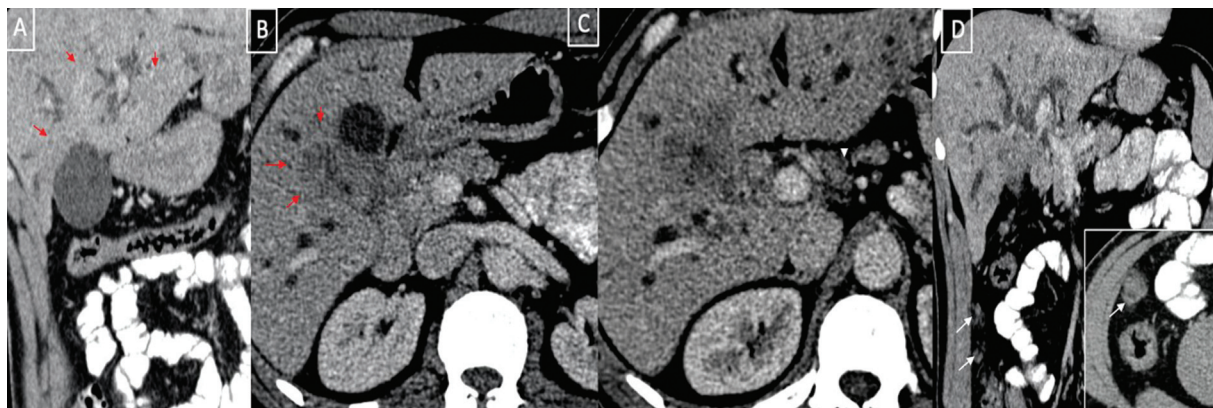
Multiplanar reformatted contrast-enhanced computed tomography image of a 56-year-old male with malignant gallbladder wall thickening. Sagittal (A) and axial (B) images show the ill-margined hypoenhancing mural thickening involving the neck of the gallbladder infiltrating into the adjacent liver parenchyma causing biliary radicals cutoff with resultant intrahepatic biliary radical dilatation. Axial (C) and coronal (D) images show the extent of the disease with periportal lymphadenopathy (arrowhead, C) and omental nodules (arrow, D).
